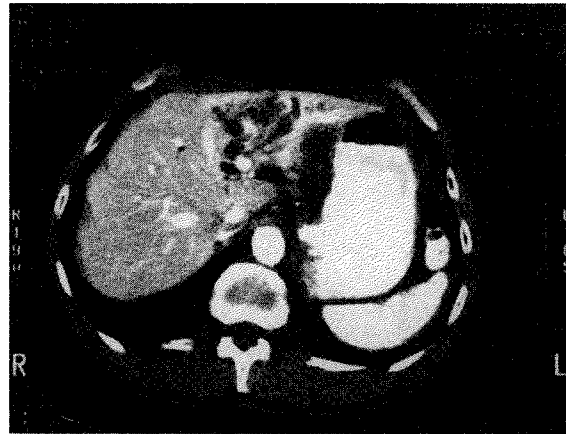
CT scan of the abdomen reveals dilated left biliary system, normal right biliary system and no evidence of a mass or tumor.
